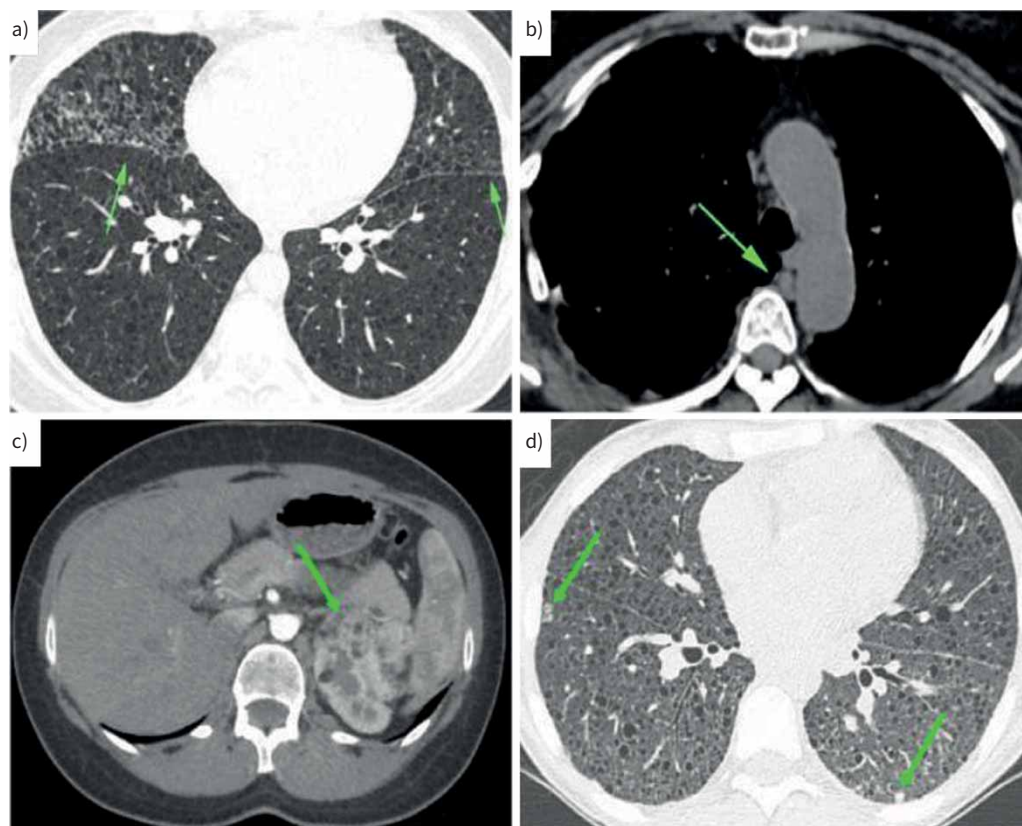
a) Axial thoracic computed tomography (CT) image shows ground-glass opacities associated with diffuse lung cysts (green arrows); b) axial thoracic CT images demonstrates lymphangioliomyoma (green arrow); c) abdominal CT image shows left renal angiomyolipoma (green arrow) in a patient with previous right nephrectomy; d) axial thoracic CT scan demonstrates noncalcified nodules (green arrows) suggestive of multifocal micronodular pneumocyte hyperplasia associated with diffuse lung cysts.
